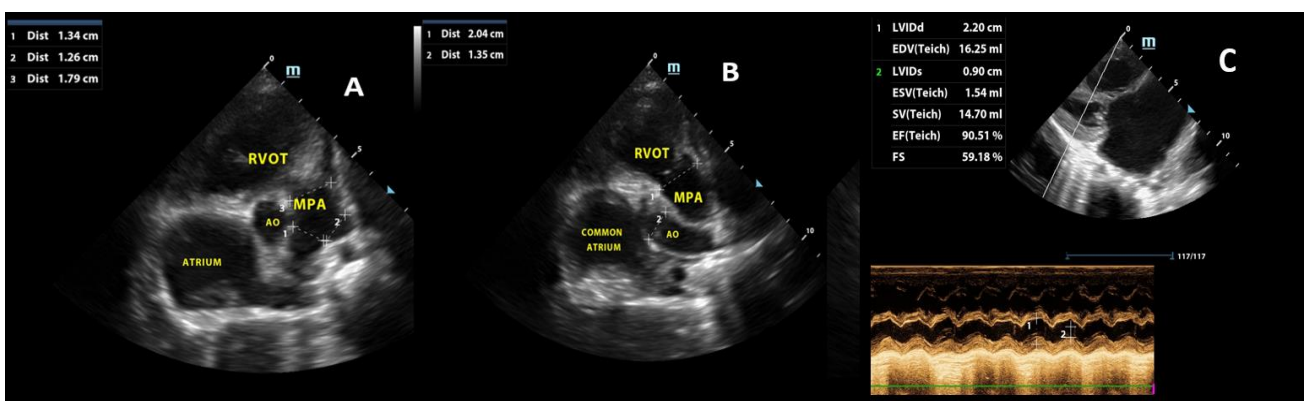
2D Echocardiogram, [A&B]short axis aortal pulmonary view: Showing main pulmonary [MPA] and its relation with the Aorta [the normal crossover], the main pulmonary artery diameter [17.9-20.4mm] is larger than the Aorta[13.5mm, the pulmonary artery to aortic ratio is 1.5, the right[RT-13.4mm] and left[LT-12.6mm] pulmonary artery are also dilated ,C] Mmode parasternal long axis view showing ventricular interdependence and ejection fraction of 90%
